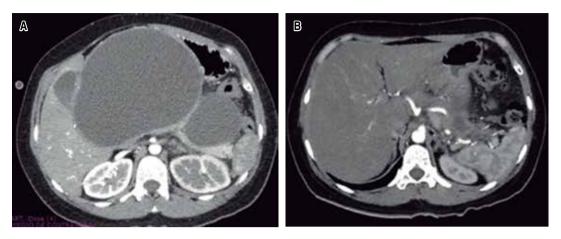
Abdominal CT scan with intravenous contrast showing the pancreas enlarged by head and body-dependent ovoid lesions, measuring $229 \times 137 \times 182$ mm with an approximate volume of 2.899 cm³, and a second lesion measuring $100 \times 57 \times 82$ mm with an approximate volume of 238 cm³. A) Cross section at its largest diameter. B) Postoperative abdominal tomography (one month).
